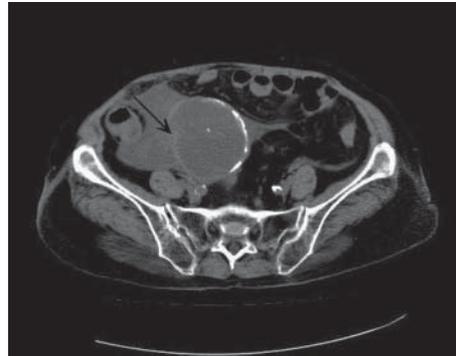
CT scans showing a ruptured round mass with calcified margin over the lower abdomen (black arrow).
